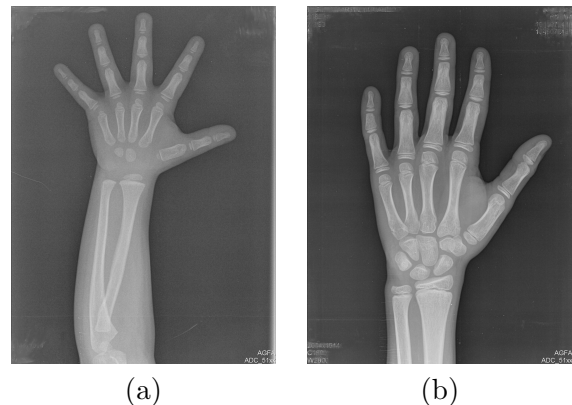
a) Hand X-ray from an early aged patient (carpal bones have not appeared, and epiphyses are small and separate from the bone); b) Hand X-ray from a higher aged patient (carpal bones are already presents, and epiphyses and large bones are starting to fuse).
